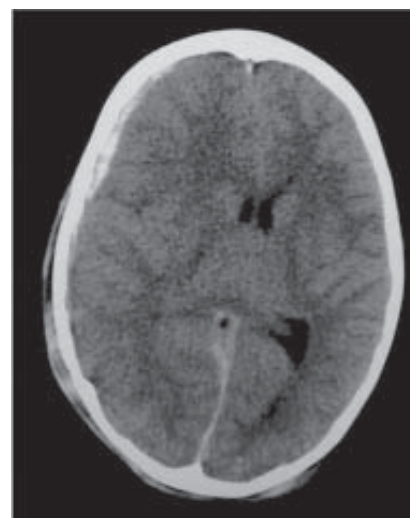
Computed tomography of head of a pediatric patient with a right-sided, acute subdural hematoma. Note the profound midline shift.
